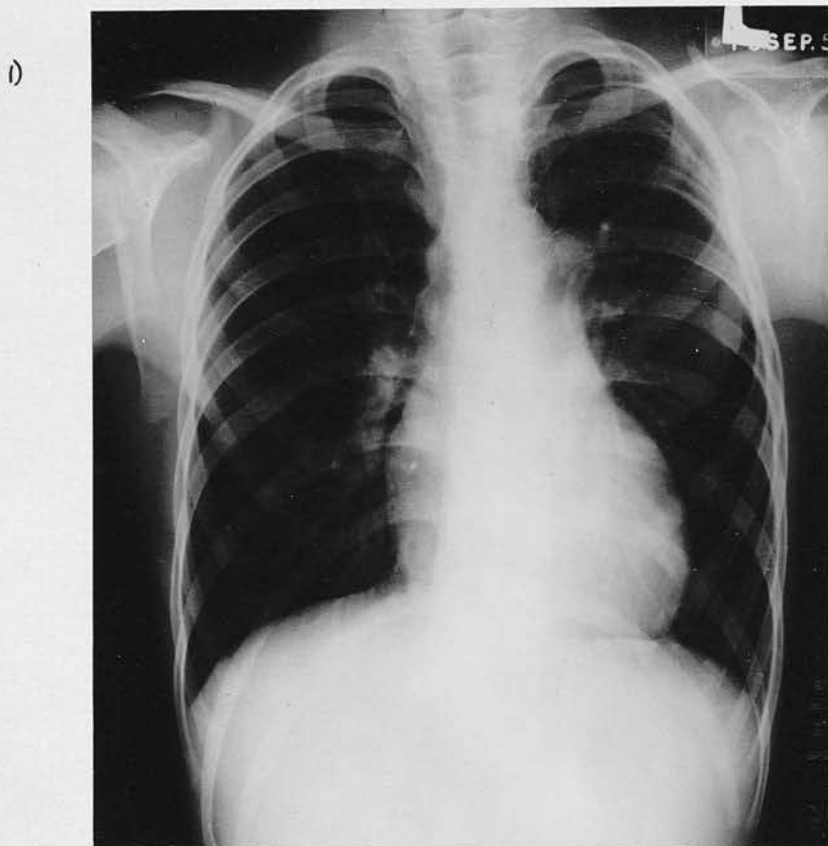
Radiograph of Case 46. Large Patent Ductus with recanalisation after ligation. Development of ?Pulmonary Artery Aneurysm.
